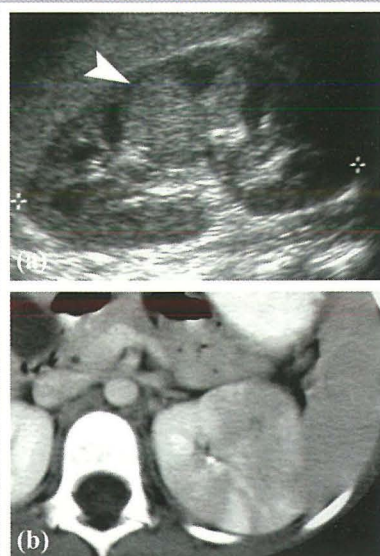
(a) US scan demonstrates a geographic, slightly lobulated "mass" (arrowhead) in the midpole of the left kidney, a finding that is suspicious for a solid tumour. (b) CT scan shows multifocal regions of diminished enhancement that extend to the periphery of the kidney, findings consistent with interstitial nephritis.
